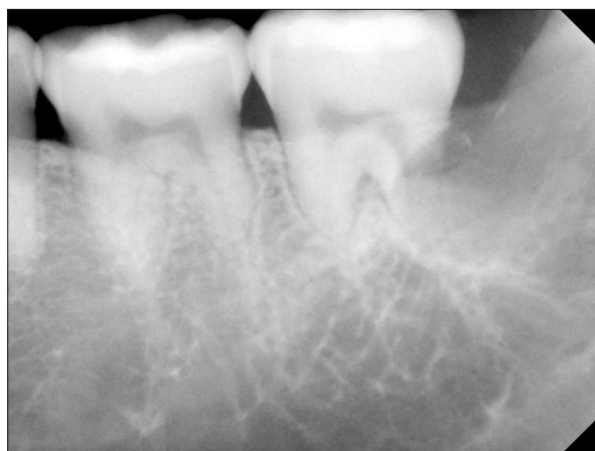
Periapical radiograph of tooth #37 showing severe root resorption around the distal root of the tooth following extraction of tooth #38.
